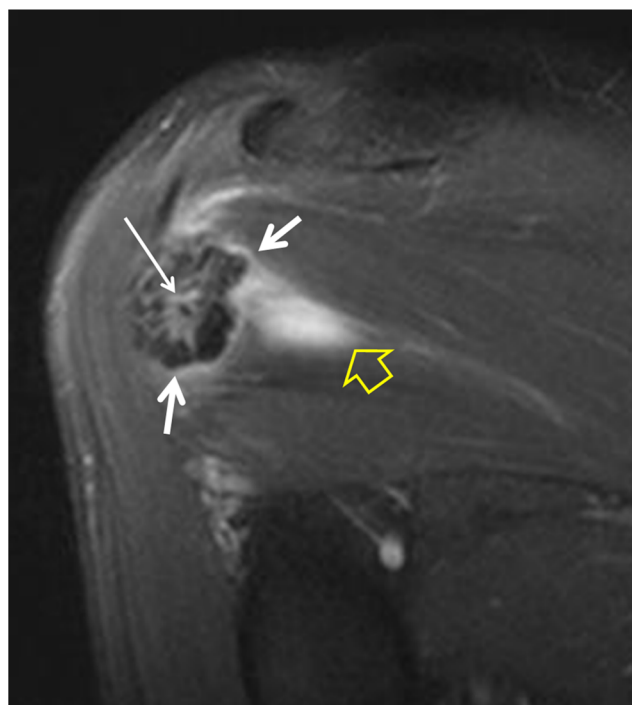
A 60-year-old female patient with a 4-month history of pain. The fat-suppressed oblique coronal PD-weighted MRI, shows the perilesional rim of oedema (arrows), the soft-tissue oedema (open arrow) and the internal high signal intensity (long arrow) in keeping with an active calcific deposit lesion
